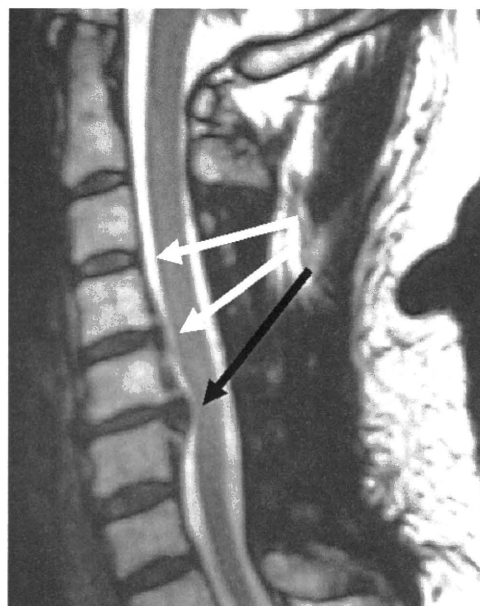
Postoperative MRI image. The white arrows indicate CF-MRI (+) lesions. The black arrow indicates a CF-MRI (-) lesion.
